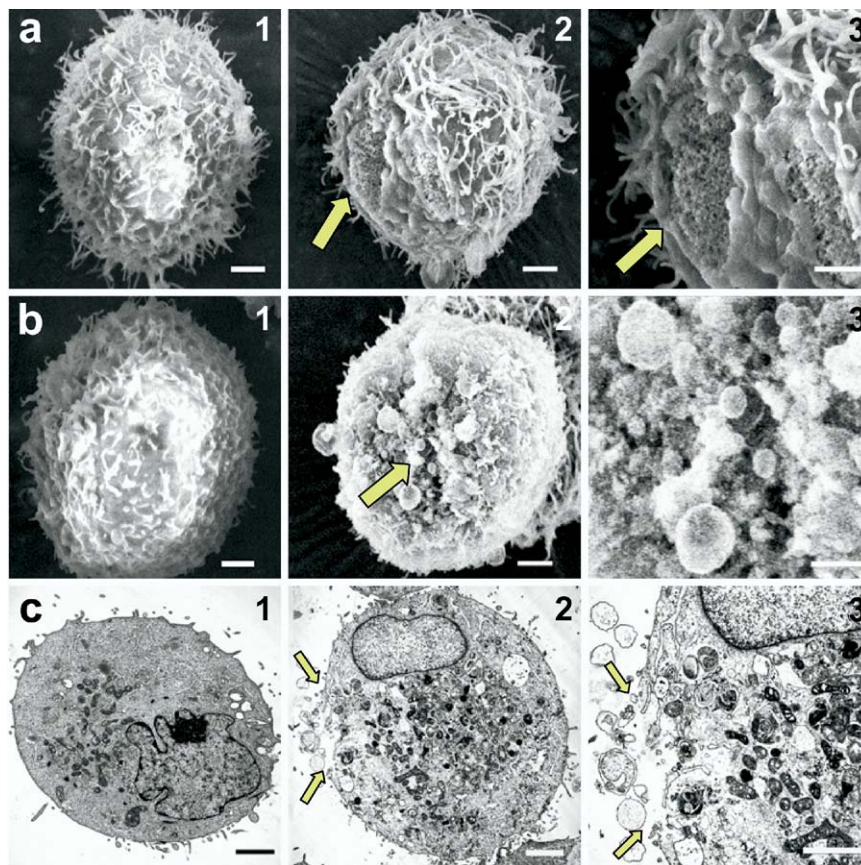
Ultrastructural analysis of ultrasound's effect on plasma membrane. (a) Evidence of structural changes in plasma membrane due to ultrasound: SEM of (a1) nonsonicated DU 145 cell and (a2,a3) sonicated cell, shown at two levels of magnification, with a region lacking characteristic membrane surface topography and revealing exposed cytoskeleton; and (b, c) evidence of repairing wounds: SEM of (b1) nonsonicated cell and (b2,b3) sonicated cell, and TEM of (c1) nonsonicated cell and (c2,c3) sonicated cell, each with membrane disruption associated with numerous vesicles believed to be of intracellular origin and that may facilitate active membrane resealing. Cells were fixed 2 s after sonication using EM-grade glutaraldehyde (Castejon et al. 2001). Scale bars are 1 μm .
